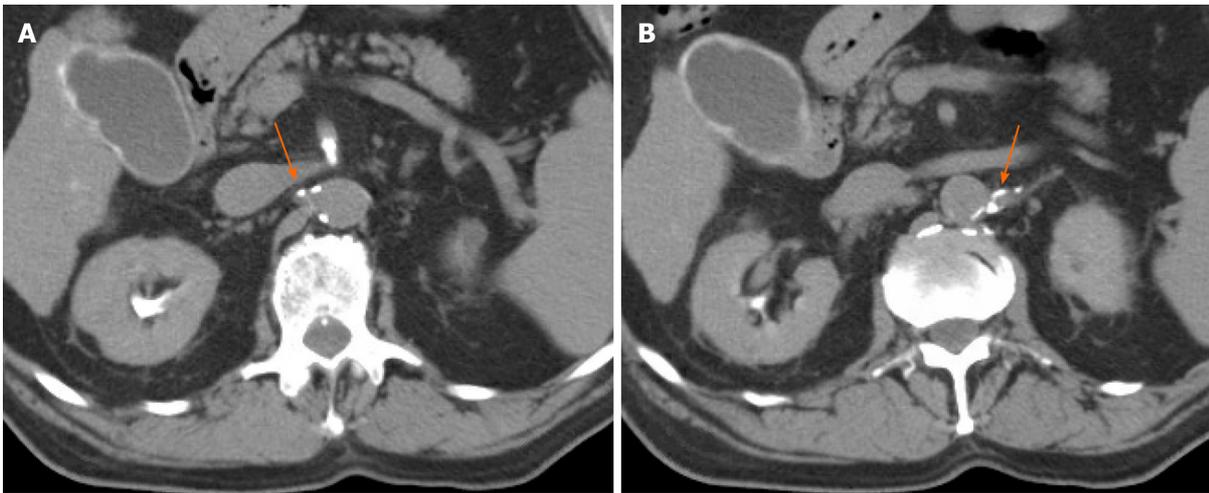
Computed tomographic. A: Immediate post-embolization non-contrast computed tomographic demonstrating homogenous renal parenchymal enhancement (renal cortex and medulla) with Hounsfield units of 172 and incomplete opacification of renal collecting system, consistent with Early Excretory renal enhancement phase. Hyper enhancement of renal parenchyma compared to adjacent paraspinal skeletal muscle is evident; B: Immediate post-embolization non-contrast computed tomographic demonstrating complete opacification of the renal collecting system with renal parenchyma iso-dense to surrounding skeletal muscle, consistent with late excretory renal enhancement phase.
